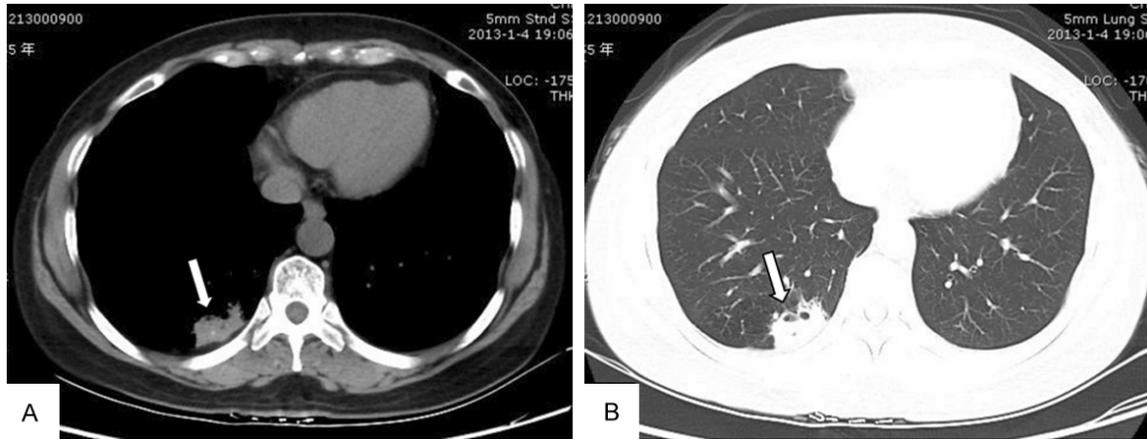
Chest high-resolution CT scanning on admission showed a nodular cavity shadow in the right lower lobe [(A) mediastinal window, (B) lung window].
